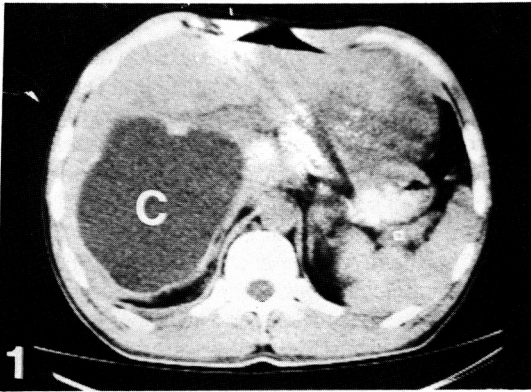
CT finding of liver which shows well-margined even, thin walled cystic mass (C) of right lobe of liver, 12cm in diameter with inner fluid density.
